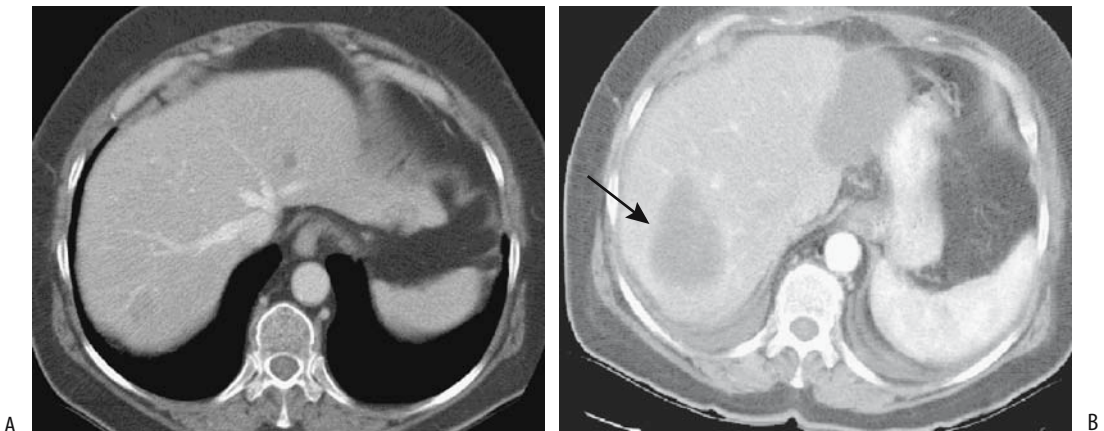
Cryoablation and resection of metastatic colon carcinoma. A: Three liver lesions are present on this pretherapy image; two left lobe ones were resected and one in the right lobe was frozen. B: Postresection and postcryotherapy CT identifies a biloma/seroma at the site of left lobe resection and a residual lesion without contrast enhancement is evident at the site of right lobe cryotherapy (arrow). (Courtesy of Fred Lee, M.D., University of Wisconsin.)
